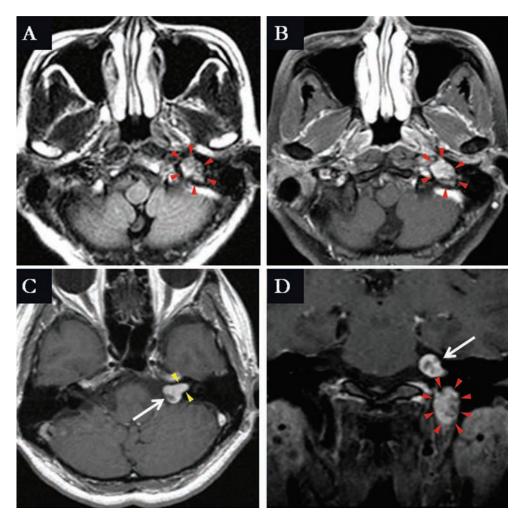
MRI of the brain with contrast showing a hypervascular mass at the left foramen jugulare (red arrowhead), and another enhancing mass at the left cerebellopontine angle (white arrow) with extension into the left internal auditory canal (yellow arrowhead).
